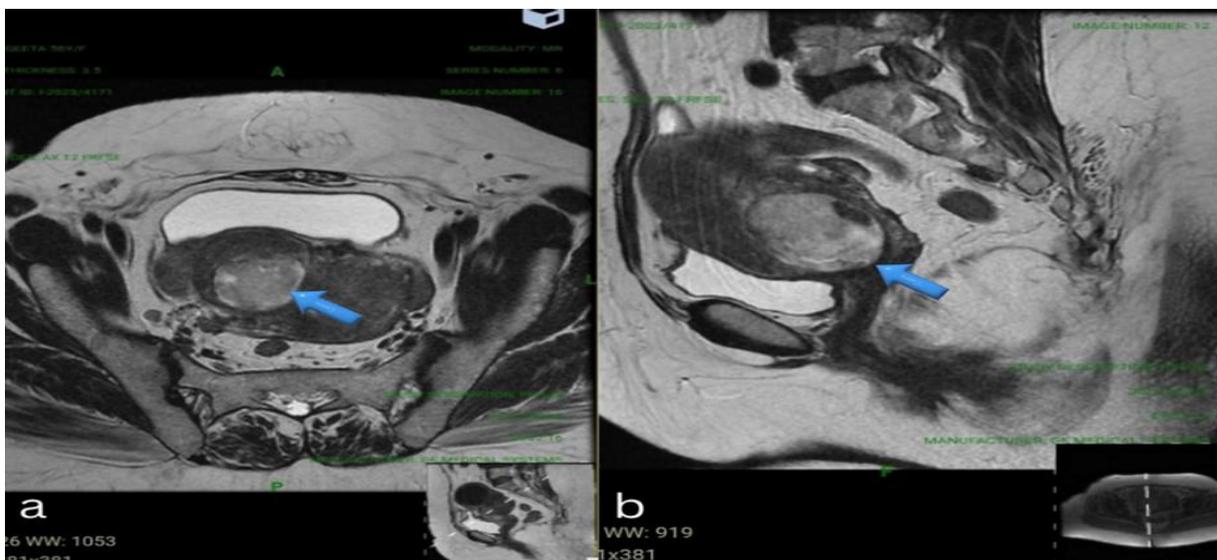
(A and B): Magnetic resonance imaging showing ULMS of a post-menopausal woman (arrow).
